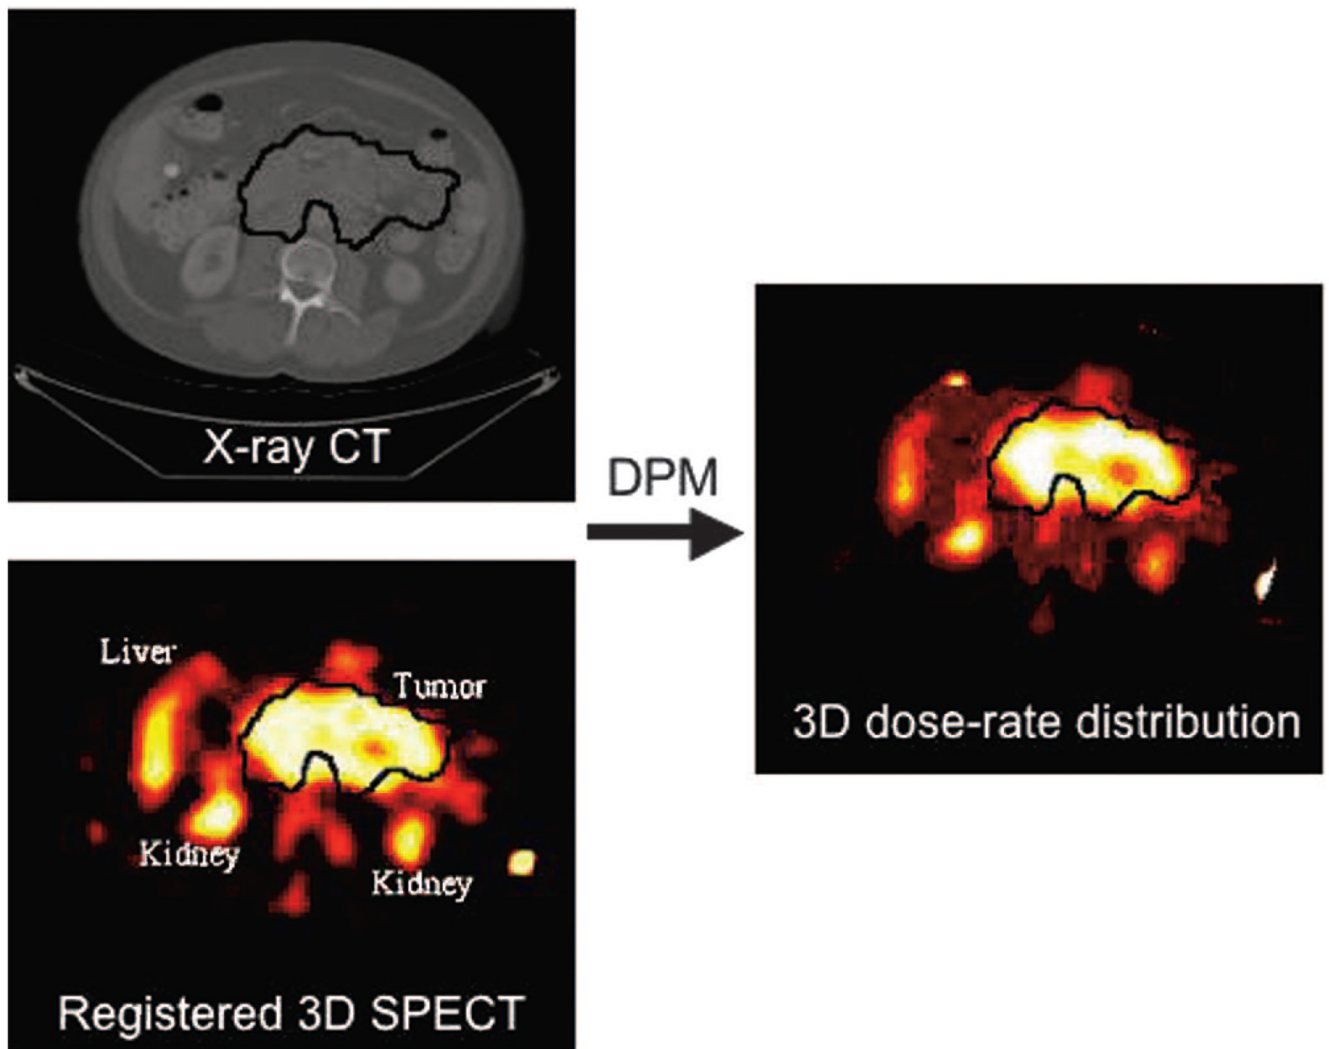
One slice of RIT patient CT image, SPECT image, and corresponding dose-rate map.
